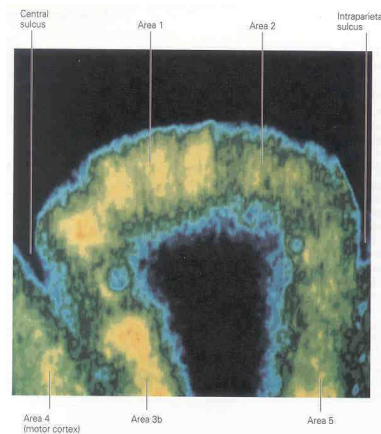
Columns from the primary somatosensory cortex shown by auto-radiography after 45 minutes of stroking a hand with a brush. On this sagittal section of the cortex a high activity (proportional to the concentration of a radioactive substance) can be viewed in areas 1 and 3b. Columns are well defined in area 1 and form a continuum in area 3b (From [22]).
